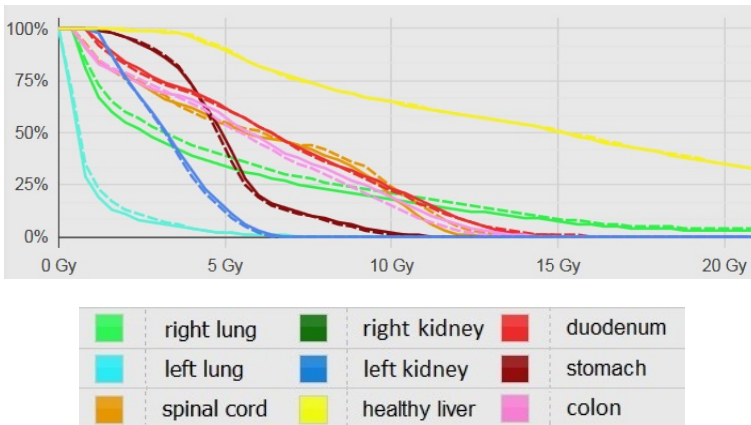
OARs DVHs for 3D dose distribution calculated by MCS on the 4D_Ph1 CT images (solid line) and 4D dose distribution calculated by MCS with fiducials tracking (dashed line), for patient 4
